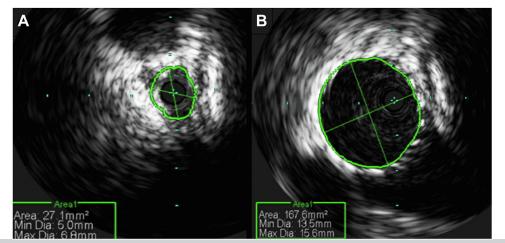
A. Intravascular ultrasound (IVUS) measures of the left common iliac vein (CIV) cross-sectional area, demonstrating stenosis. B. IVUS of the same area after stenting.
